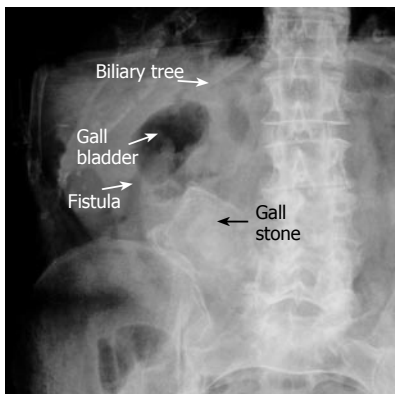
Plain X-ray showing air in the biliary tree and an ectopic bizarre-shaped gall stone suggesting the diagnosis of cholecystoenteric fistula.
